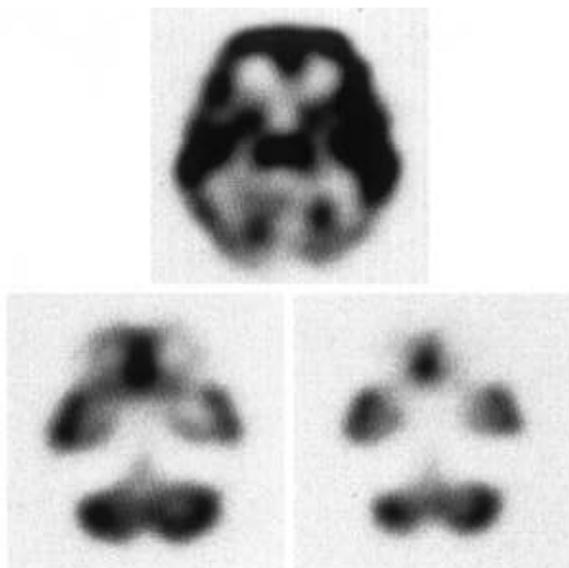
28-year-old female with MJD. IMP SPECT shows marked decreased accumulation in the brainstem. The C/O ratio was 0.89, the B/O ratio was 0.63. (C: blood flow of cerebellum, B: blood flow of brainstem, O: blood flow of occipital lobes)
